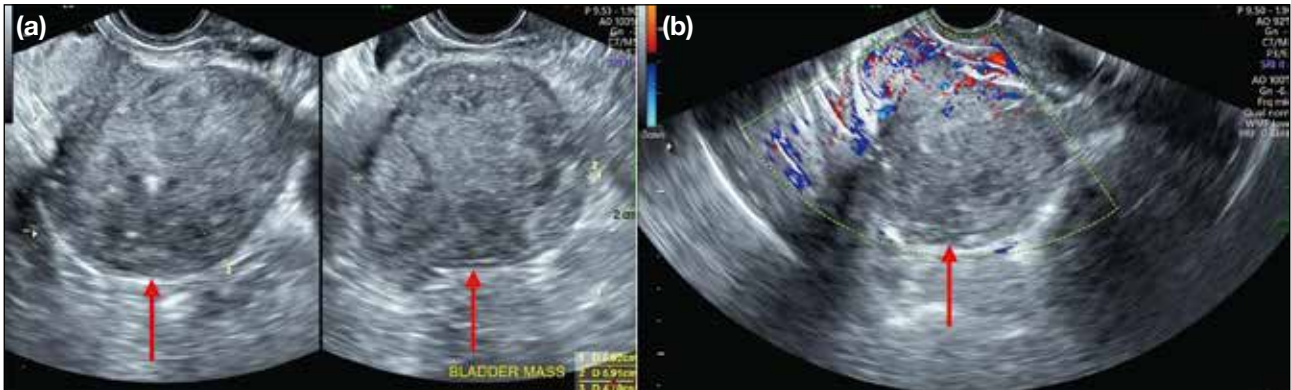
Transvaginal ultrasonography. (a) Slightly irregular ovoid solid mass (arrows) extending from the posterior urinary bladder wall, measuring $6.9 \times 5.9 \times 4.7$ cm³. (b) Doppler interrogation showing moderate vascularity of the mass (arrow).
